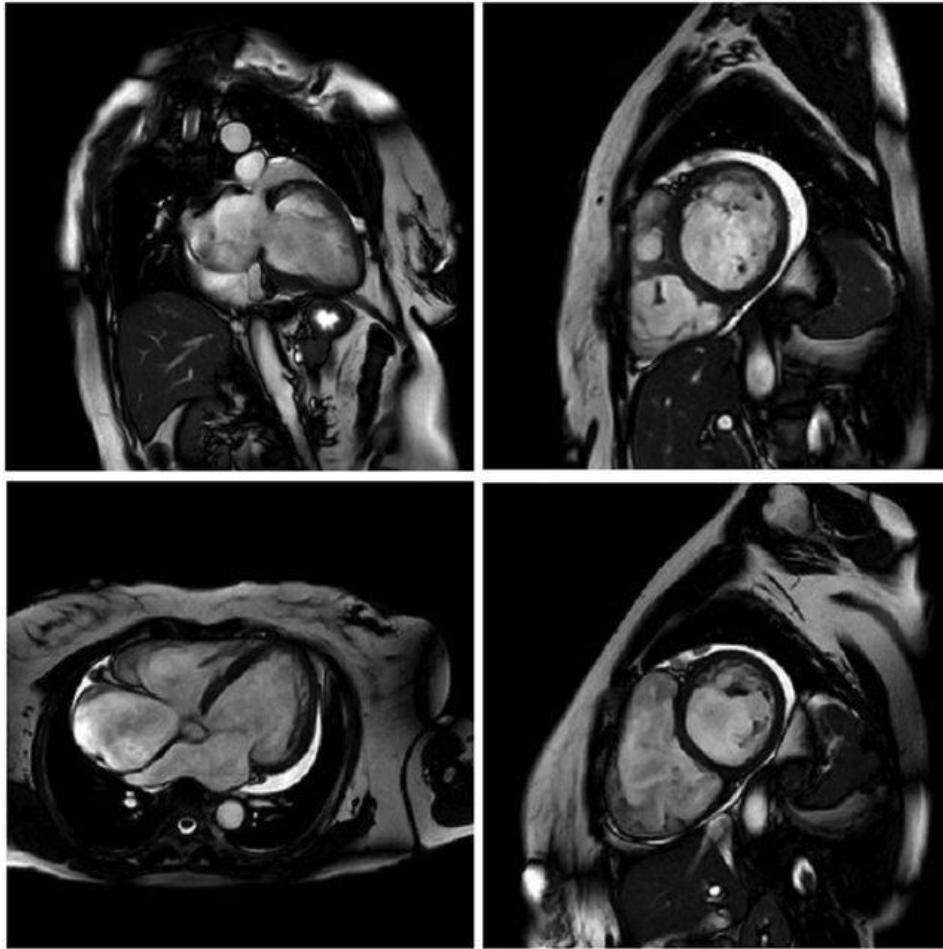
Magnetic resonance imaging (MRI) for Heart Failure (19)
